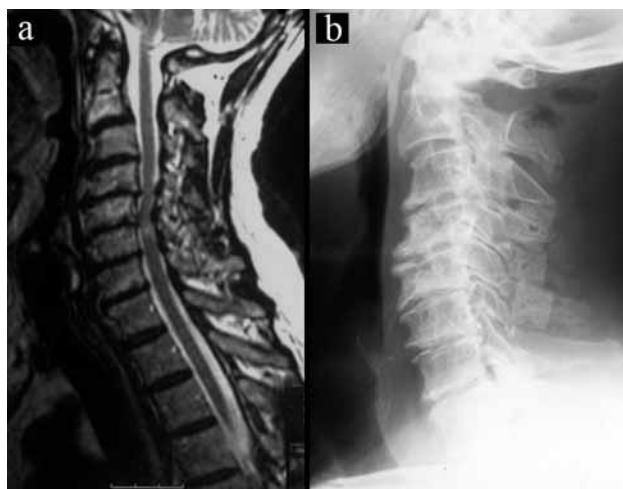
(A) Preoperative MRI of a 60-year-old man with cervical spondylotic myelopathy. (B) Postoperative radiography after French-door laminoplasty. In this case of three-level stenosis, allografts for median reconstruction at C4,C5, and C6 levels were used.
